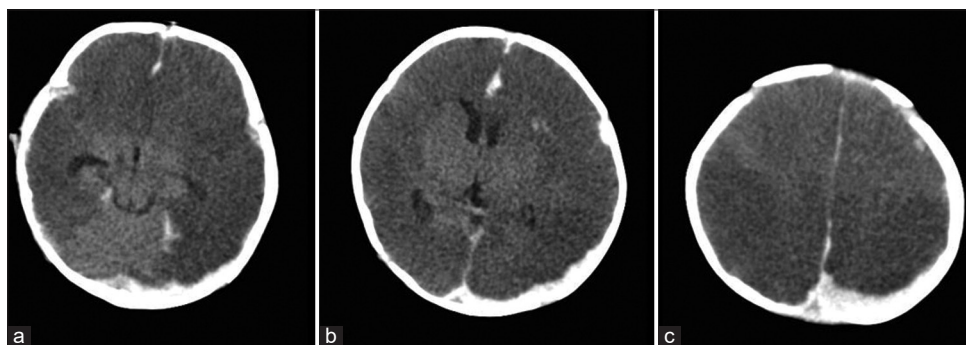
Non-contrast computed tomography scan. (a) Bilateral hemispheric hypodensity with preservation of posterior fossa was seen, consistent with a “big black brain” (b) Preservation of central nuclei was also seen, along with a left hemispheric crescentic lesion, suggestive of a subdural hematoma. (c) The hypodense lesion was also seen up to the vertex region.
